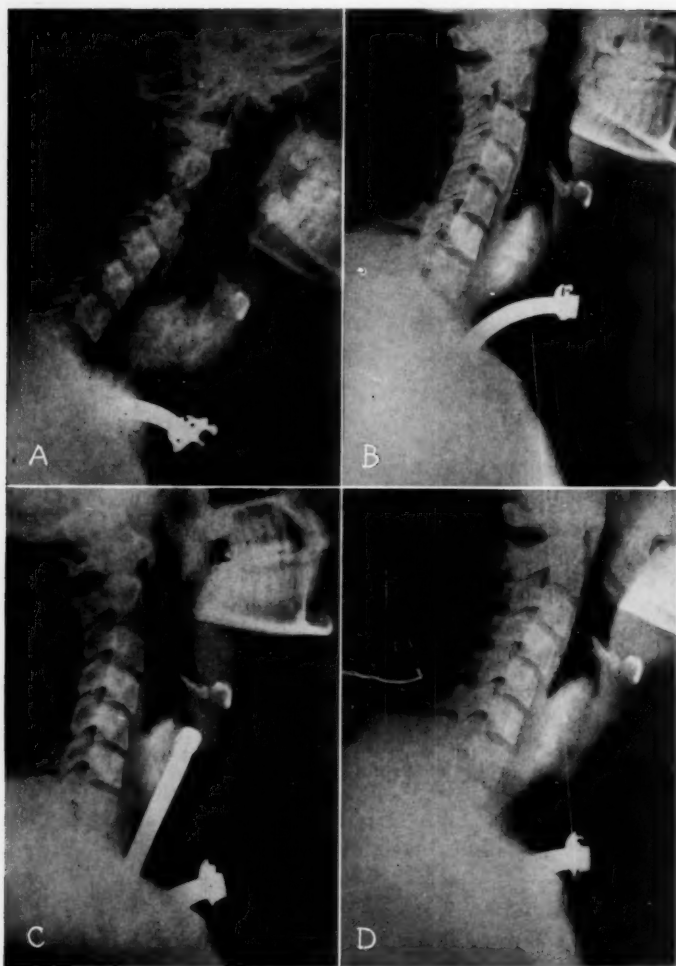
A. Lateral x-ray of the neck of a 21-year old man shortly following an automobile accident. The crushed, swollen larynx, extensive cervical emphysema, obliteration of the airway and high tracheotomy are shown. B. X-ray demonstrating partially healed, stenotic larynx three weeks later. C. Tracheotomy tube lowered and intralaryngeal splint inserted to re-establish the airway and maintain the position of the cartilages. This step should have been taken as early as possible after the accident, but fortunately, patency of laryngeal airway was re-established. D. X-ray prior to removal of tracheotomy tube.
